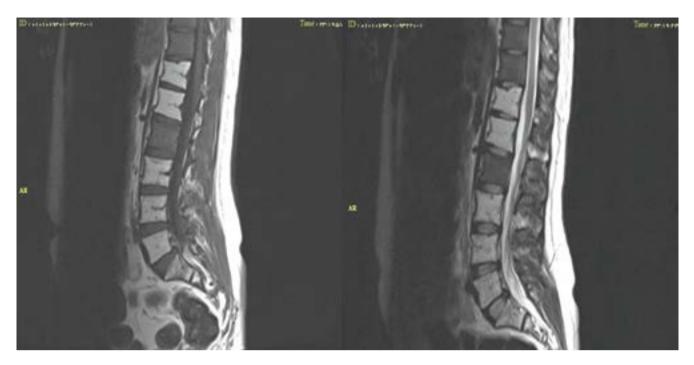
Spine MRI revealed multiple hypersignal vertebrae on T1 (left) and T2-weighted (right) sections in T12, L1, and L3-L5 vertebrae
